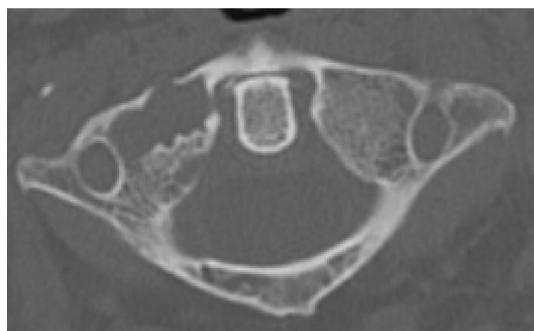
Axial cervical CT—osteolytic lesion centered to right anterior mass, arch and facets with anterior cortical disruption
